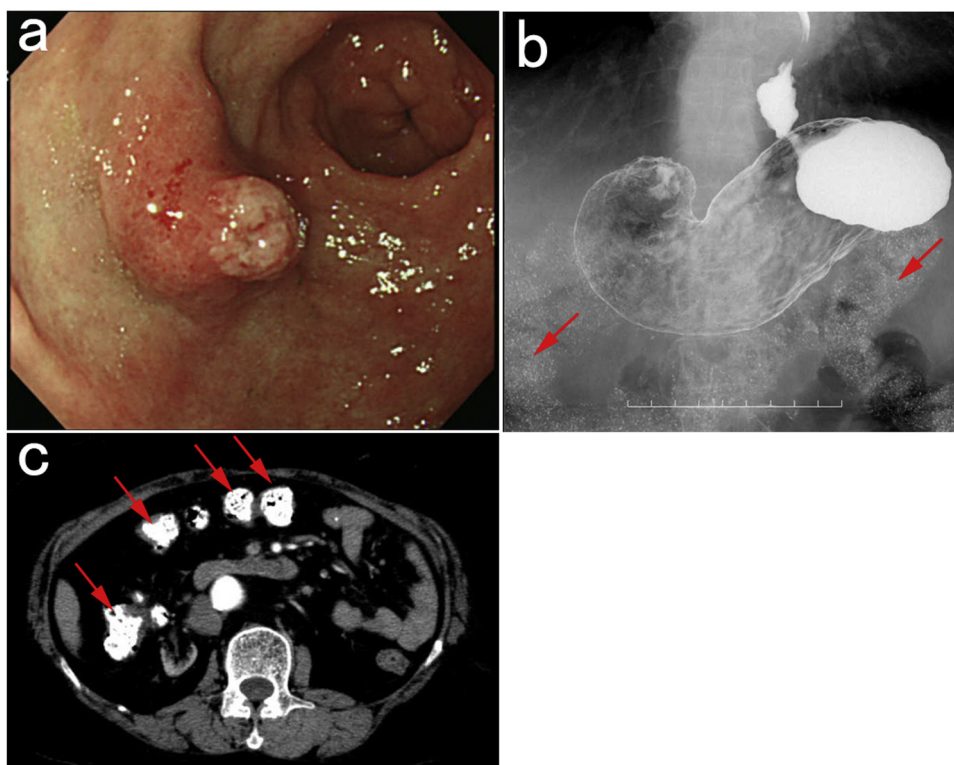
Endoscopic findings of case 1, which shows a protruding lesion with atrophic gastritis in the antrum of the stomach (a). In gastrointestinal series (b) and computed tomography (c), numerous radio-opaque microparticles or positive contrast (arrows) are seen in the intestine.
